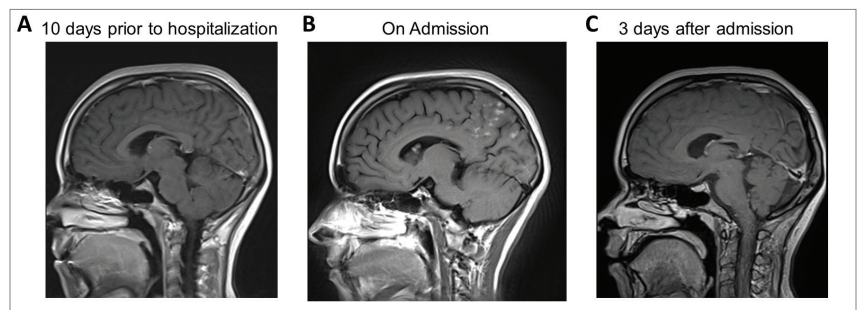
A comparison of T1 Sagittal FLAIR post-contrast MRIs of the brain taken (A) 10 days prior to patient presentation, (B) on presentation to the ED, and (C) on hospital day 3. Notice the diffuse hyper-intense lesions with periventricular and leptomeningeal involvement with resolution of enhancements on MRI conducted on hospital day 3.
